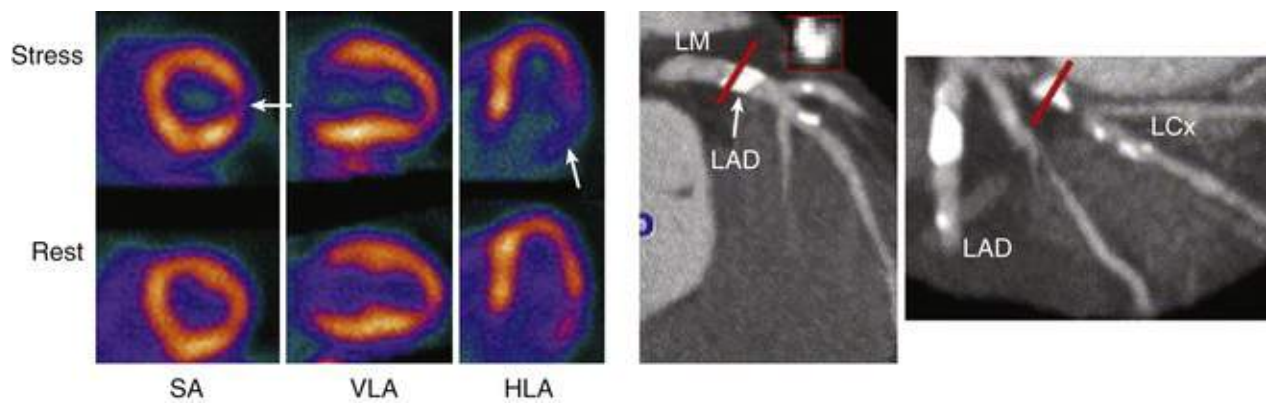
Combined PET images of stress and rest perfusion (left) and cardiac CT angiography and calcium imaging (right). The PET images demonstrate a lateral wall reversible defect consistent with ischemia (arrows in short-axis [SA] and horizontal long-axis [HLA] images). VLA, Vertical long-axis view. However, the CT images demonstrate more extensive calcification and stenosis of the left main (LM), left anterior descending (LAD), and left circumflex (LCx) vessels. The combined information suggests that although the physiologic ischemia predominantly involves the lateral wall–LCx territory, more extensive CAD is present. Red lines represent planes for cross-sectional views of coronary arteries (not shown).
